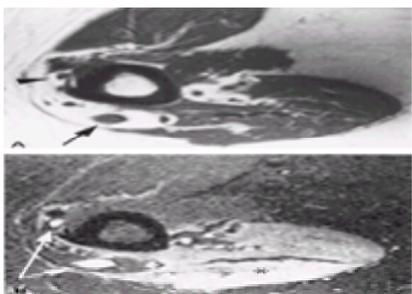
Ulnar and radial nerve injury. This patient suffered a severe left brachial plexus injury, with radial and ulnar neuropathy. A: T1-weighted axial image through the left upper arm showing location of the radial (*arrow*) and ulnar (*arrowhead*) nerves. T1 sequences generally demonstrate anatomic relationships better than corresponding short tau inversion recovery sequences. B: Short tau inversion recovery image showing increased signal in radial and ulnar nerves (*arrows*) as well as increased signal in triceps muscle (*asterisk*).
